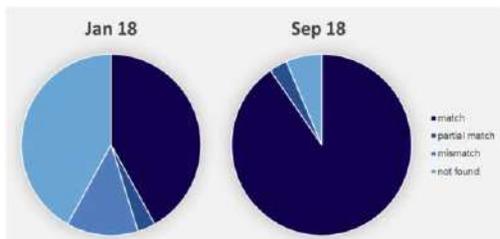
Assessment of 62 data elements at the MRI at two time points
